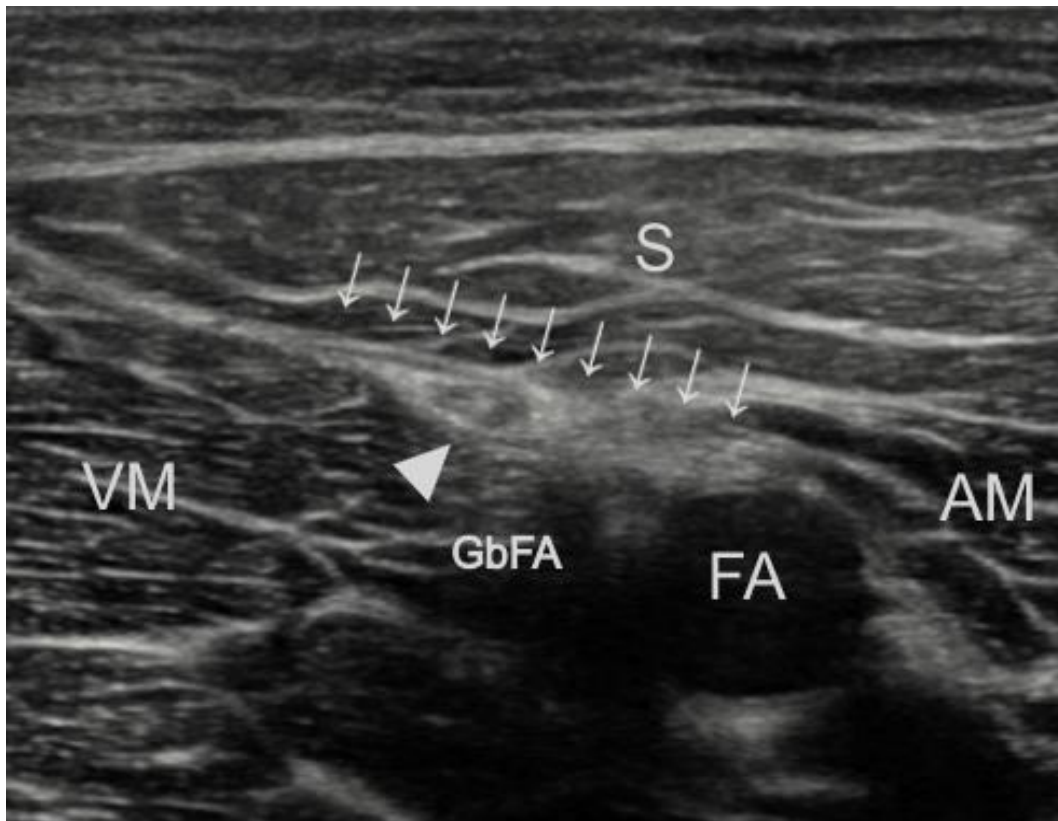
Ultrasound Investigation Inner Thigh
